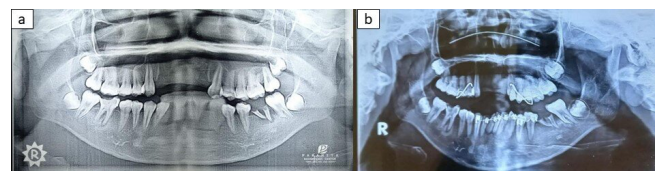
Pre and post treatment Orthopantomogram (OPG). Figure 4a: Preoperative orthopantomogram (OPG) pretreatment. Showing dentoalveolar segmental fracture in anterior mandible and teeth missing #12 #11 #21 #22. 4b: Twentieth day orthopantomogram (OPG) indicating bone remodelling at #41 #42 #31 #32 #33 area.
